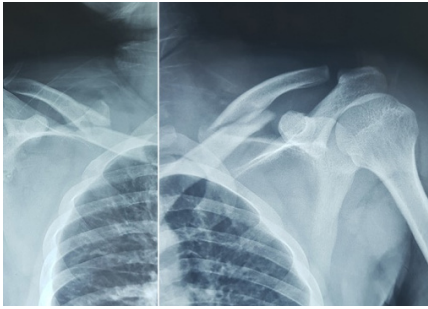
First X-Ray showing left midshaft clavicular fracture and comminuted right midshaft clavicular fracture with displaced subscapular fossa.
